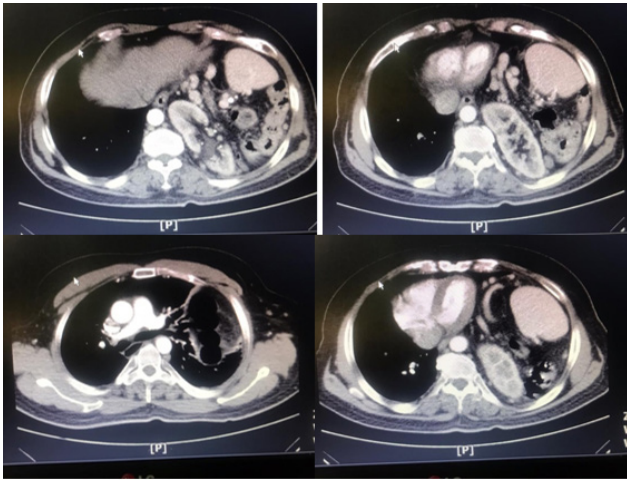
CT scan of the thorax and abdomen with oral and intravenous contrast.
